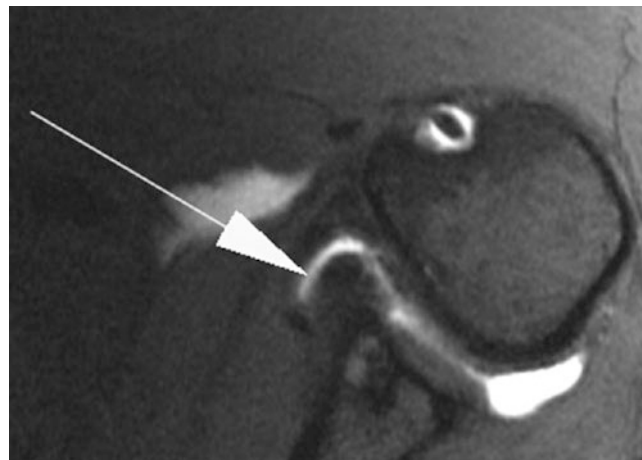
Axial FS T1-weighted image from direct MR arthrogram demonstrates a normal postoperative globular anterior inferior labrum (arrow) following soft tissue Bankart repair. Note how the anterior glenoid “bumper” has been restored, and no contrast is seen undercutting the labrum
